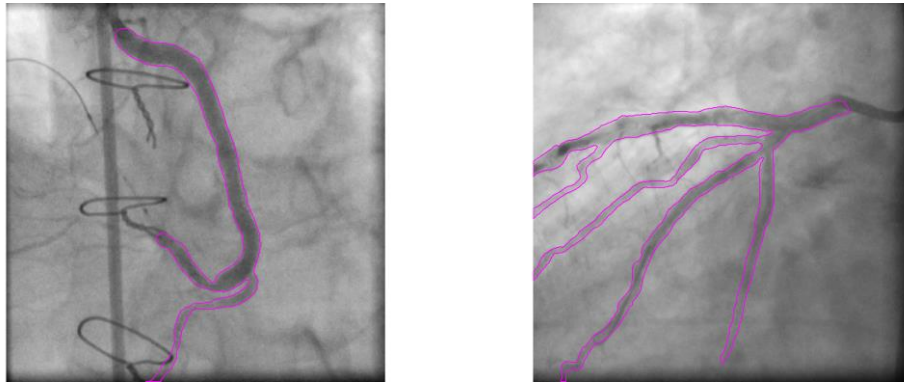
Manual masks (colour lines) on X-ray 1 (left) and X-ray 2 (right).
